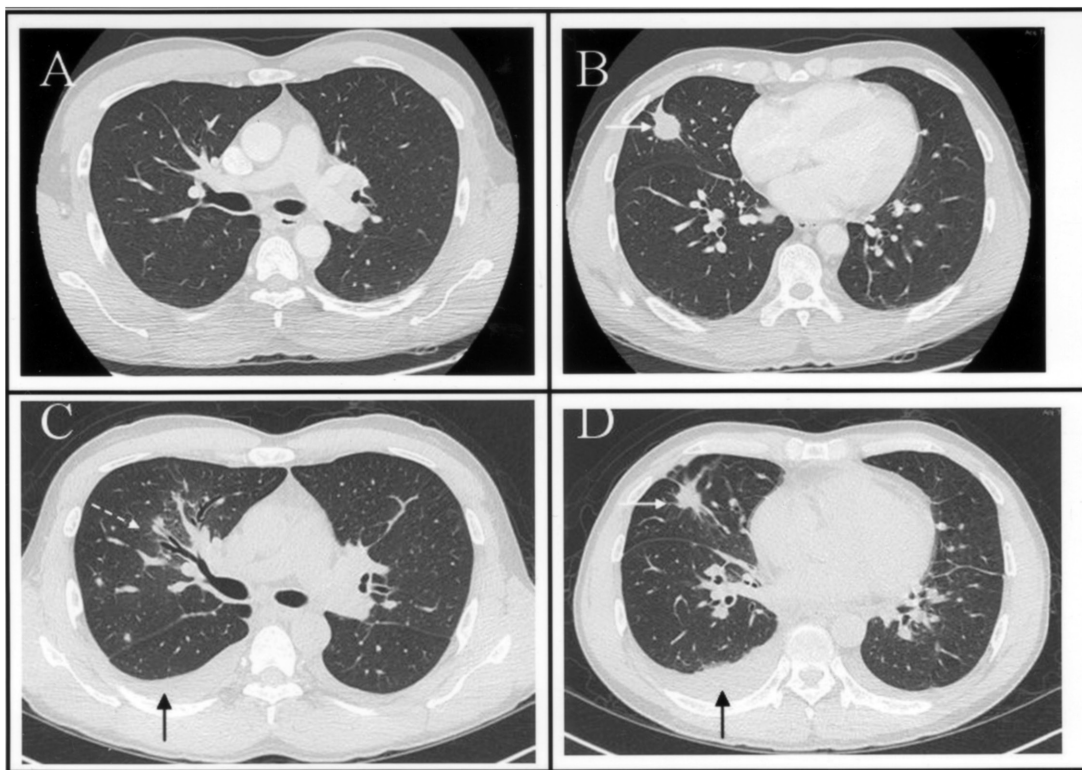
Before gefitinib treatment: (A) Chest CT scan before gefitinib treatment and through the carina level, demonstrated normal lung parenchyma. (B) Chest CT through the right middle lobe (RML) demonstrated a 2.6 cm lobulated nodule (white arrow) in the RML with heterogeneous enhancement and pleural tail sign. Two days after stopping the 50-day gefitinib treatment: (C) Chest CT scan showed ground-glass opacities with central peribronchial wall thickening and small consolidations (white dashed arrow). (D) Chest CT through the RML, showed small consolidations in the RML and left lingular lobe, right pleural effusion (black arrow) and a decrease in the size of the lobulated neoplasm (white arrow).
